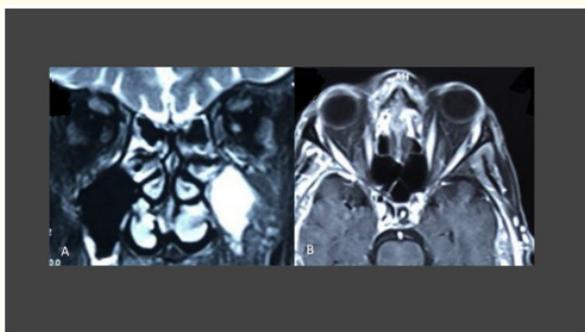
In MRI pictures of same patient 1 year after concurrent treatment with radiotherapy and vismodegib consumption, there is no remarkable thickening and enhancement after contrast injection (A and B).
